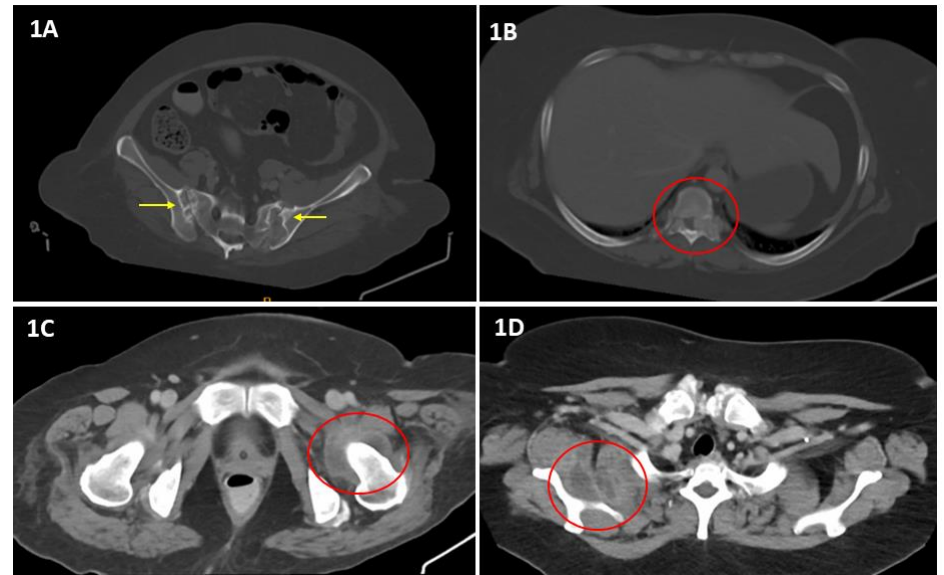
CT images of the contrasted CT thorax, abdomen and pelvis on axial view. Well-defined subchondral erosions with punched out appearances and sclerotic margins are seen at bilateral sacroiliac joints on bone window (A). Multilevel irregular dense spinal tophi, most significant at bilateral T8 pedicles and more pronounced on the left, with intraspinal extension resulting in spinal canal stenosis. This is well demonstrated on bone window (B). On soft tissue window, multiple intramuscular rim-enhancing collections are demonstrated in the left hip (C) as well as right subscapularis and adjacent levator scapulae muscles (D).
